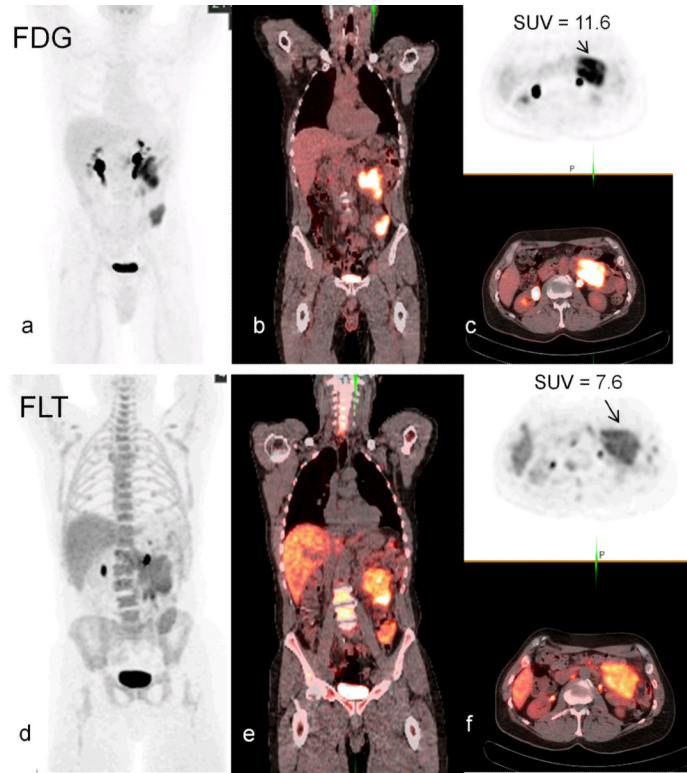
Comparison of PET/CT scans of the same patient with abdominal lymphomas using the tracers ^{18}F -FDG (a,b,c) and ^{18}F -FLT (d,e,f) (MIP (a,d), coronal fused (b,e) and axial/axial fused views (c,f))
